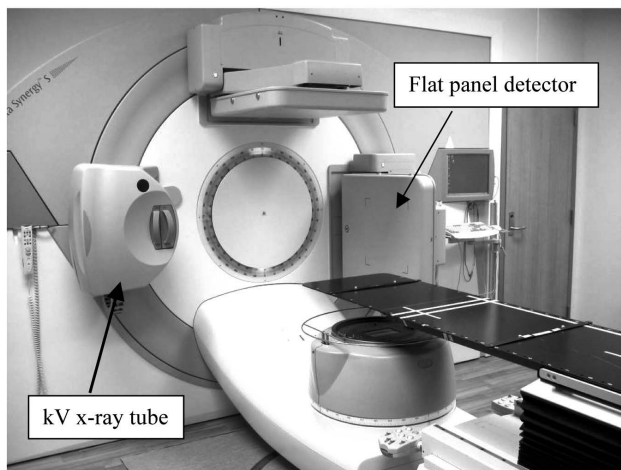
A Serial Processing Volumetric Imaging System Incorporated Into LINAC; a Set of X-Ray Tube and Flat Panel Detector is Installed Orthogonal to the LINAC Gantry
